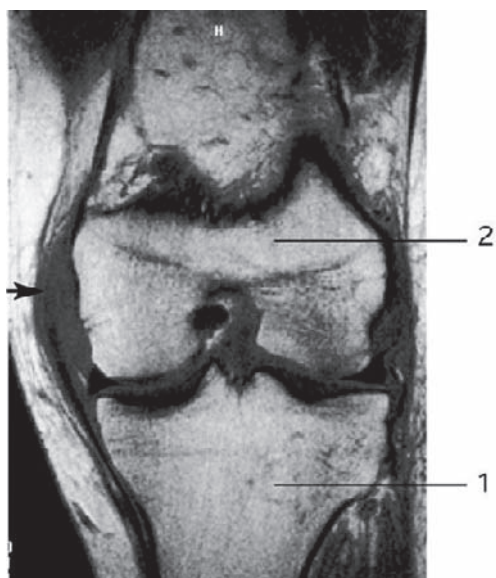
Magnetic resonance imaging showing a total rupture of the medial collateral ligament in the knee joint (arrow). 1: Tibia; 2: femur.
